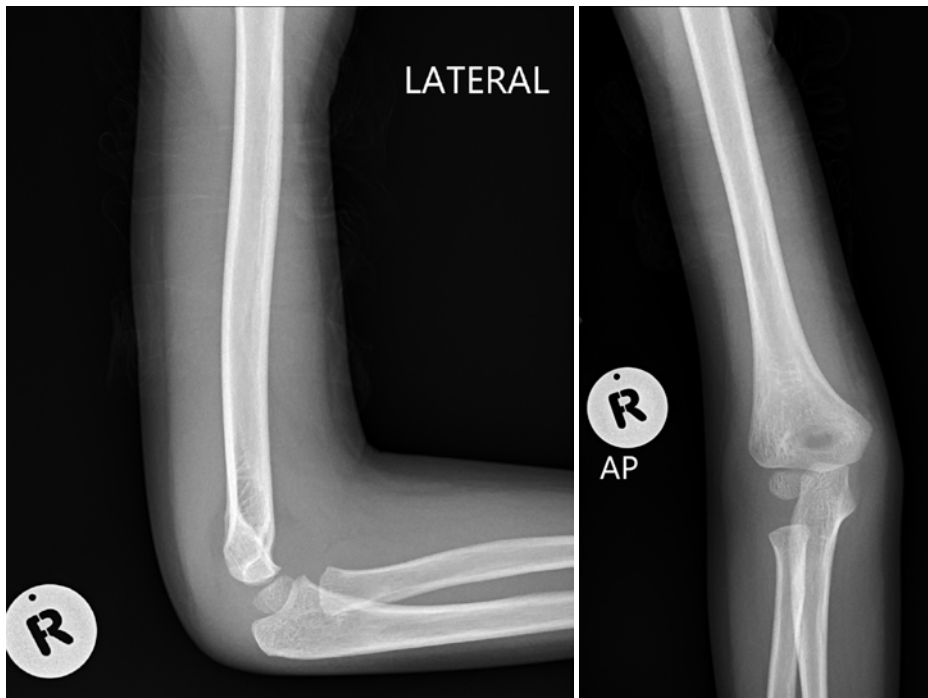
Lateral and AP radiograph of slide 12 (pre-tutorial) and slide 6 (post tutorial)
